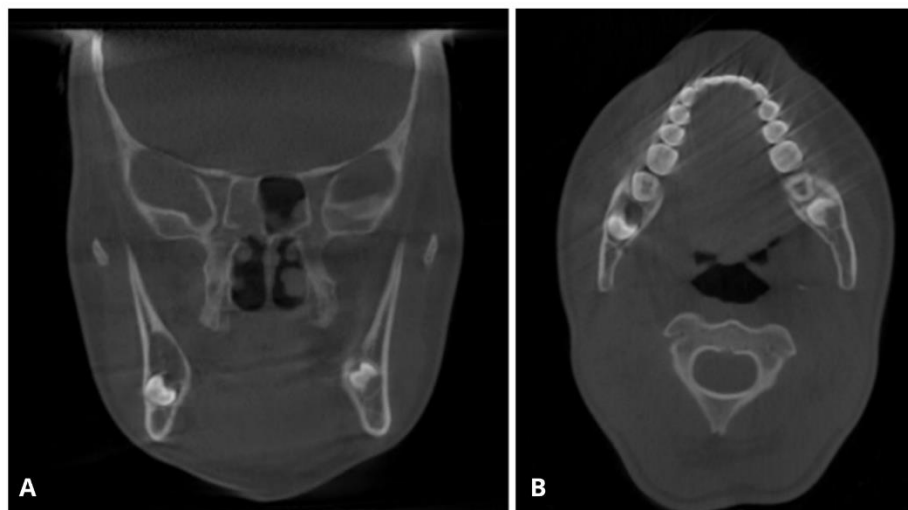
(A) Coronal CBCT section showing mediolateral extension of the lesion toward both the buccal and lingual aspects without cortical bone expansion. (B) Axial CBCT section demonstrating anteroposterior extension of the lesion from the mesial aspect of the mandibular right second molar to the inferior portion of the mandibular ramus.
